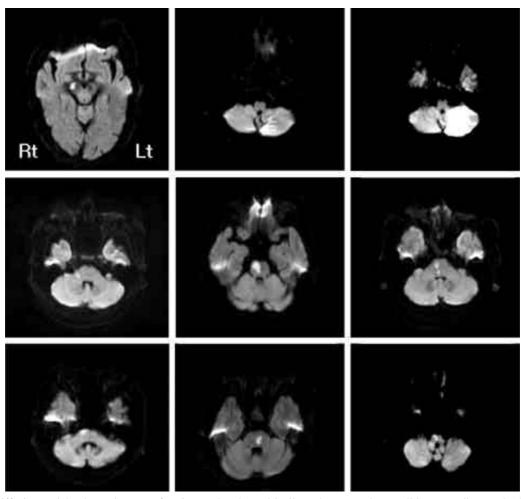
Diffusion weighted MR images of patients who showed ipsilateral VEMP abnormalities according to the lesion(1 midbrain, 2 cerebellum, 5 pons, 1 medulla lesion).
